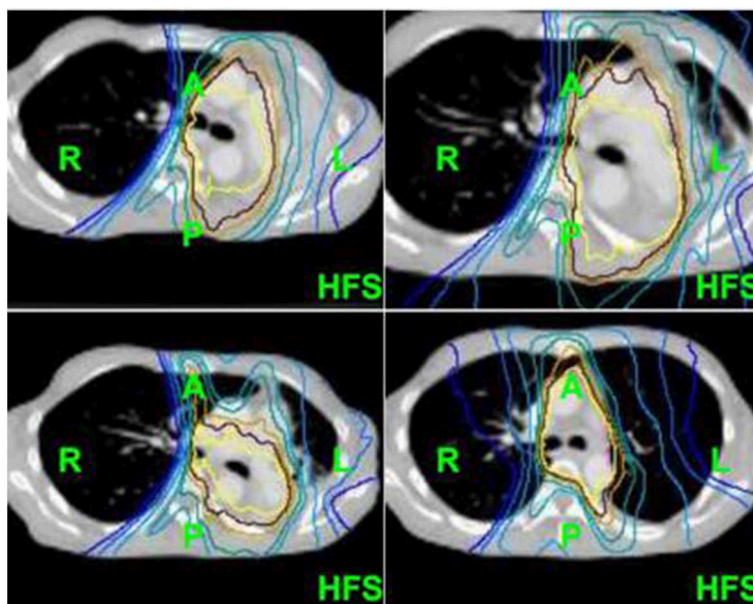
The change in atelectasis on CT images with the fraction dose.
